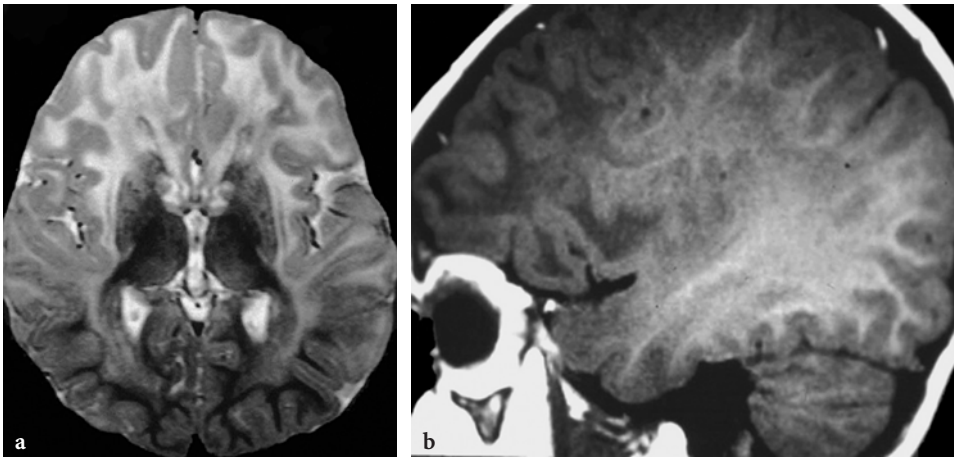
MR imaging findings in a 3-year-old female patient with the infantile form of Alexander disease (courtesy of Dr. K. Chong, London, United Kingdom). a Axial T2-weighted spin-echo image. Extensive supratentorial white matter abnormalities. The subcortical U-fibers are involved in the frontal regions and spared in the occipital lobes. The basal ganglia are also abnormal. b Sagittal T1-weighted spin-echo image. The antero-posterior gradient of the white matter disease is well appreciated
